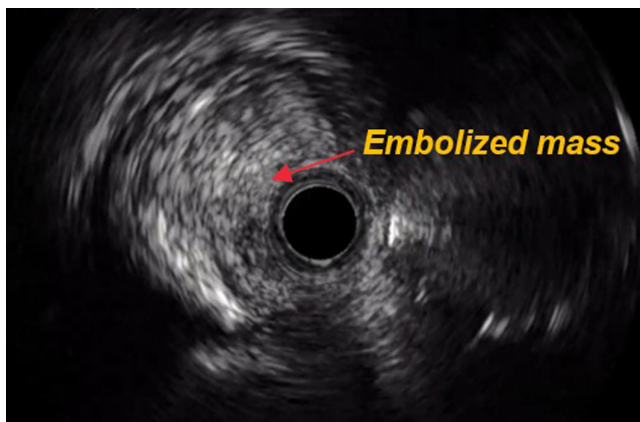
Still image of intravascular ultrasound (IVUS) of left anterior descending (LAD) showing heterogeneous, hypoechoic mass in ostial LAD with mild calcification, consistent with embolized valve leaflet tissue.
